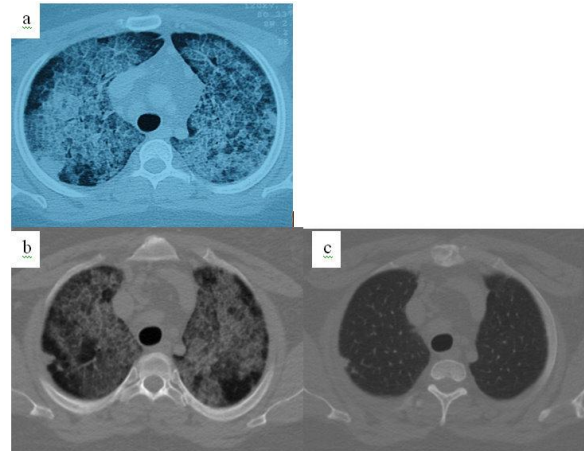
Thorax CT: a. Ground-glass density with significant interlobular septate on both lung parenchyma (crazy-paving configuration). b. Thorax CT after a year and consecutive 7 BAL procedure; minimal regression was determined. c. Significant regression during the last follow-up visit.
